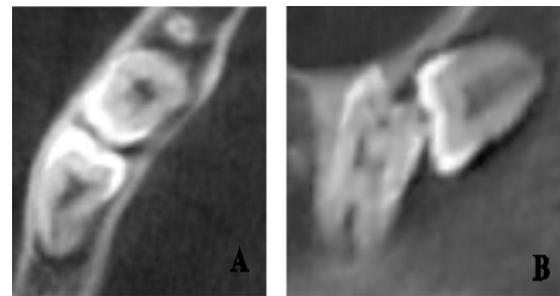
Cone-beam computed tomography images of the mandible (A) in the right and (B) left quadrant.
